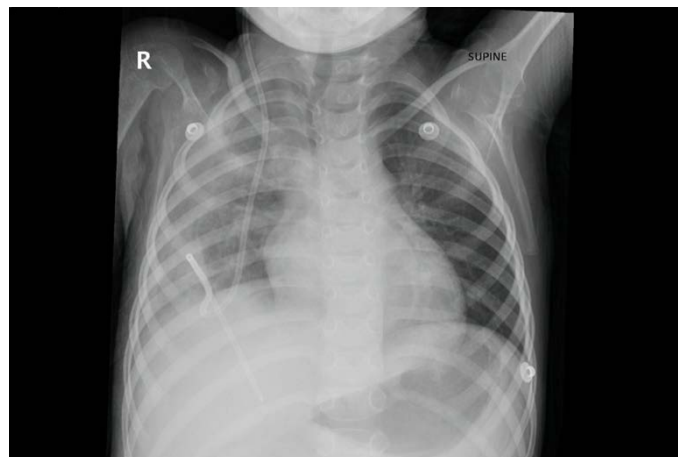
Chest Xray showing distal ventriculopleural shunt
